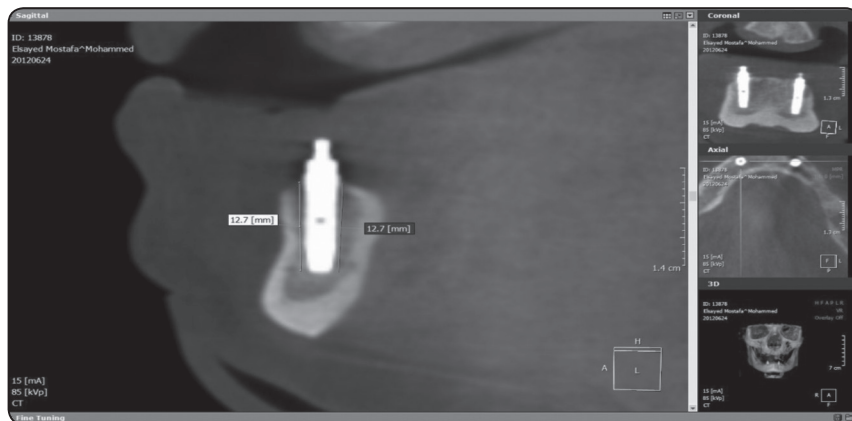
Measurement of Labial & Lingual bone height changes using CBCT in sagittal view.
